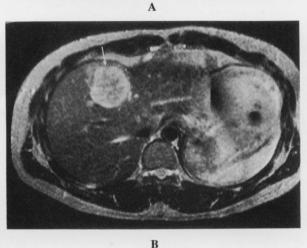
Well differentiated HCC. A. GSA SPECT shows increased accumulation in segment VIII (arrow). B. The lesion exhibits hypointensity on the T2-weighted MR image (white arrow). C. CTAP shows increased portal perfusion (arrowheads).
